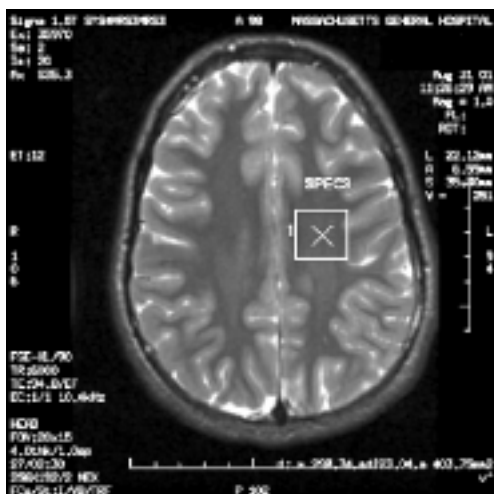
Brain MRI of patient showing no focal areas of abnormality in white matter. X marks area used for MRS.
